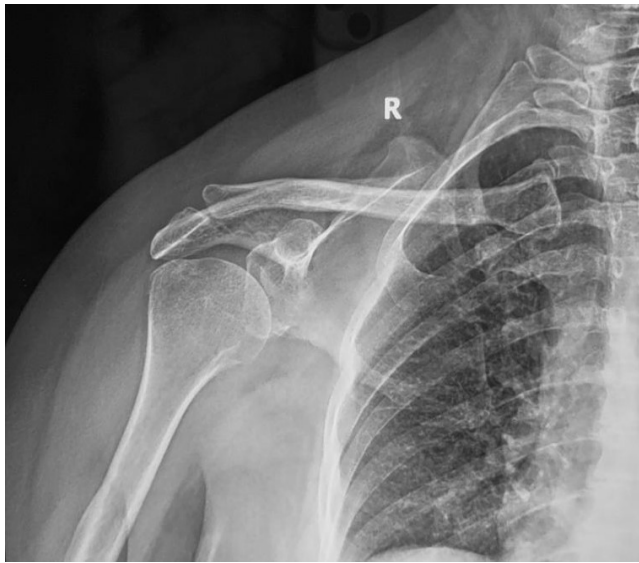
Anteroposterior radiograph of the right shoulder shows resolution of the lesion after 12 months of treatment.
